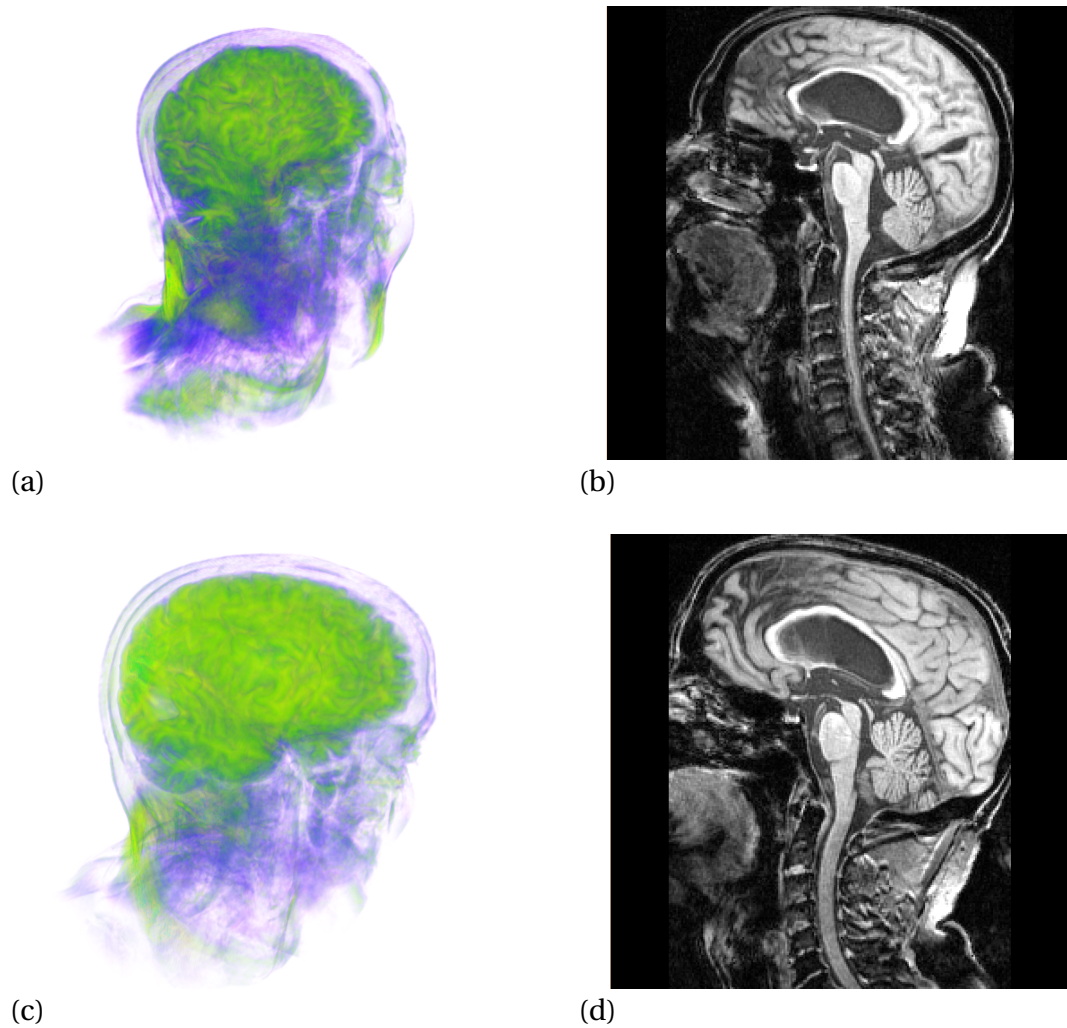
Patient-specific MRI scans: (a), (b) Case 2, a mid-seventies female patient with history of dementia, urinary incontinence and falls; and, (c), (d) Case 3, an early-seventies male patient with a history of short term memory loss and a shuffling gait.
